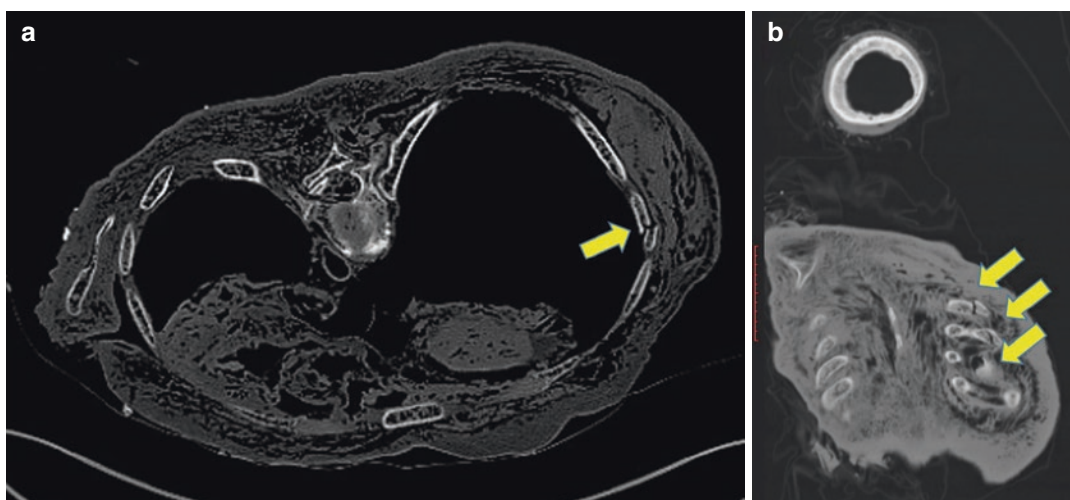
Images of PMCT of a decomposed body, acquired in prone position, show multiple costal fractures in axial (a) and coronal MPR (b) 128 rows CT images
